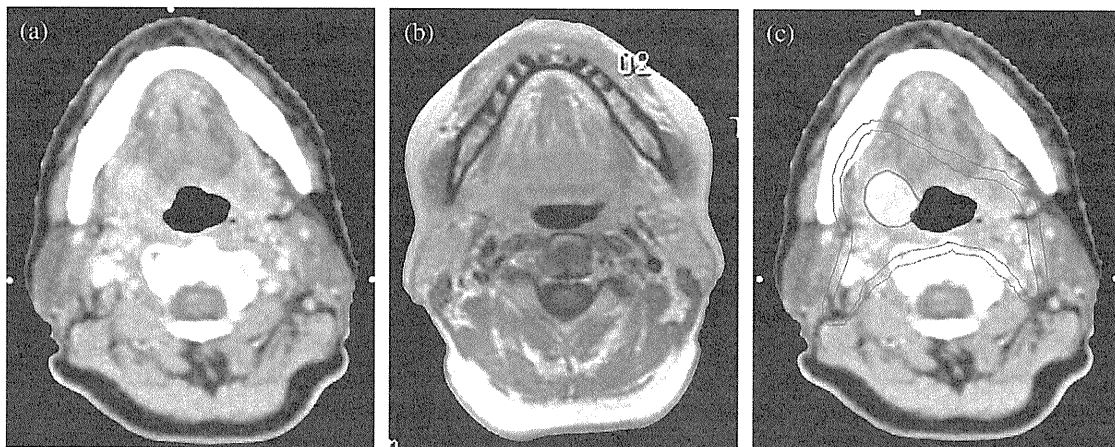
CT (a), MRI (b), and PET (c) images of a pharyngeal tumor in the axial plane. The pharyngeal tumor was unclear on CT (a) and MRI (b) images. (c) A fused PET/CT image delineated the pharyngeal tumor clearly. The internal line shows the clinical target volume, and the external line shows the PTV.
